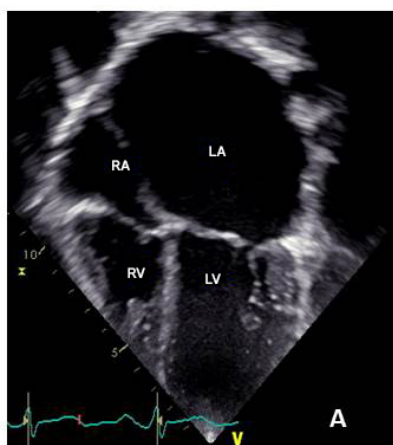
Echocardiogram showing the marked enlargement of the left heart cavities, especially the left atrium in A and B, due to the evident mitral regurgitation in B. The close connection of the leaflets with the papillary muscle occurs without chordae tendineae in C and D. RA: right atrium; LA: left atrium; RV: right ventricle; LV: left ventricle; PM: papillary muscle.
